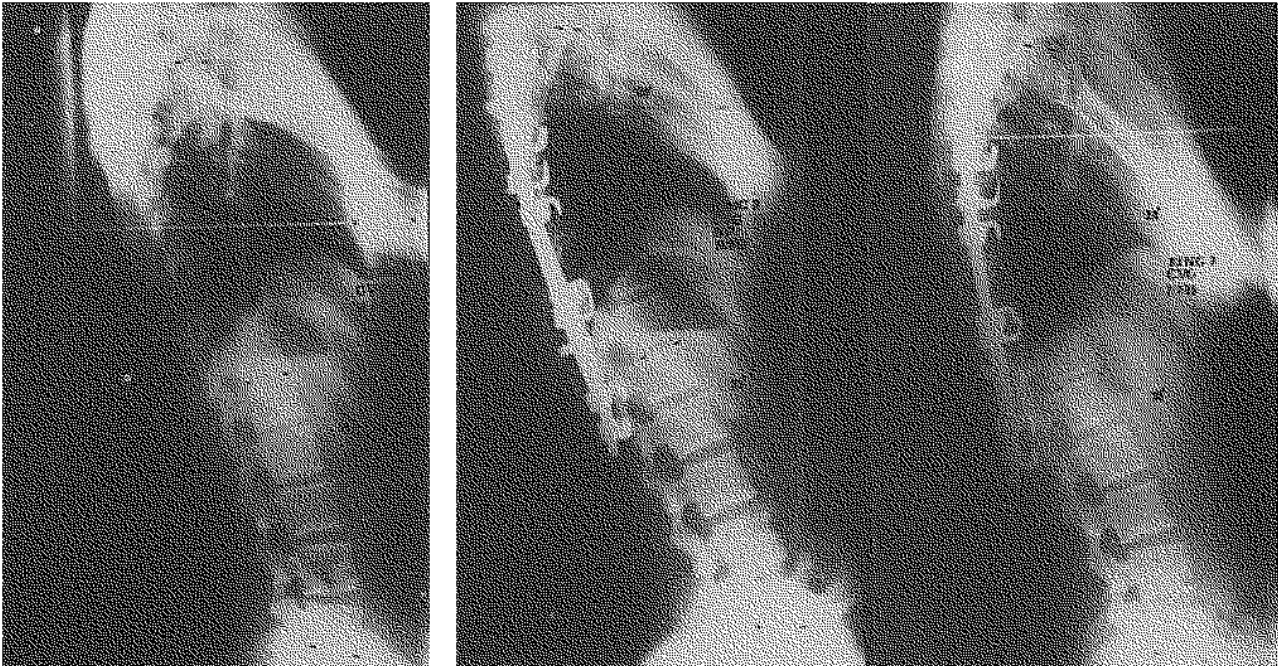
Preoperative, postoperative and follow-up lateral radiographs of a 15-year-old girl with a King type III curve. Great improvement of thoracic kyphosis can be seen with mild increase in the last revision. Lumbar lordosis has not changed significantly.
